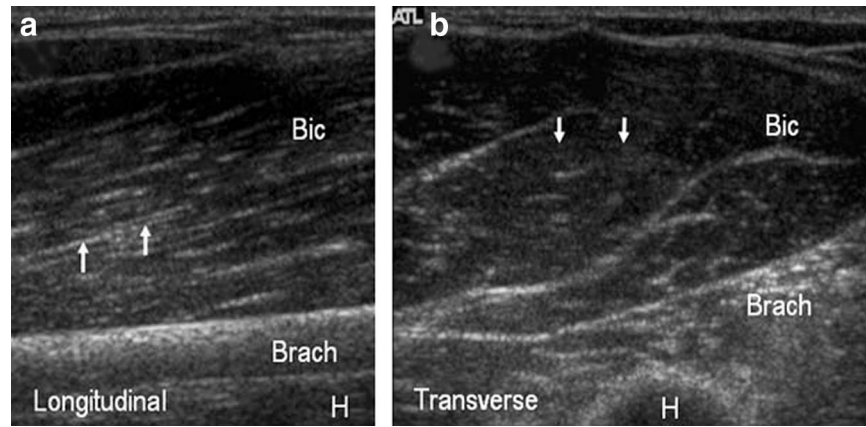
Normal biceps brachii muscle. a, Longitudinal sonogram showing intramuscular septations (arrows) seen as hyperechoic lines separating hypoechoic muscle bundles. b, Transverse sonogram showing the intramuscular septations (arrows) that appear as hyperechoic dots on a hypoechoic background. Bic, biceps brachii muscle; Brach, brachialis muscle; H, humerus.
